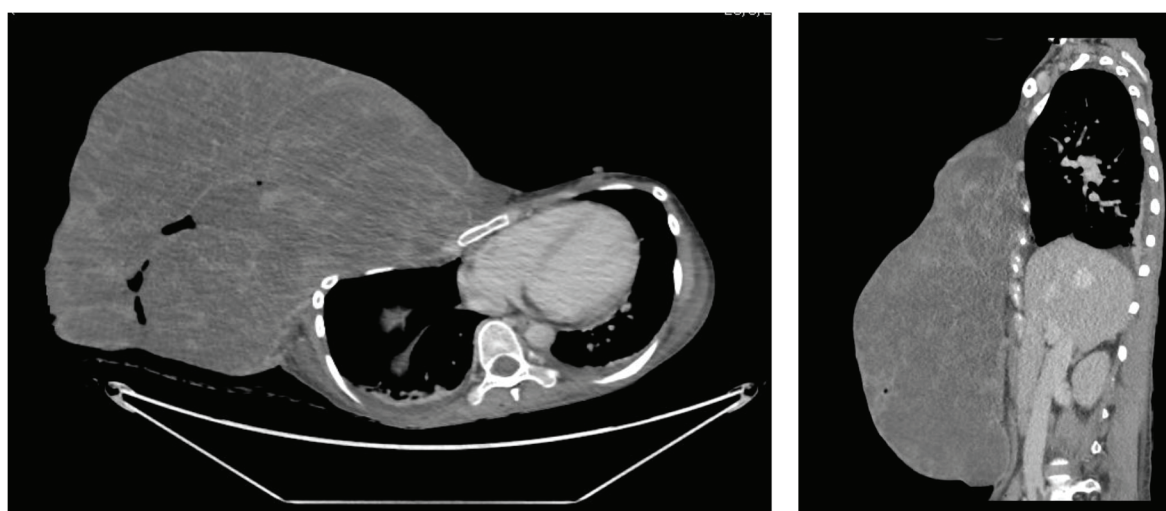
CT scan of a large ulcerative heterogeneous enhancing mass at right breast, invading the pectoralis muscle without rib destruction
